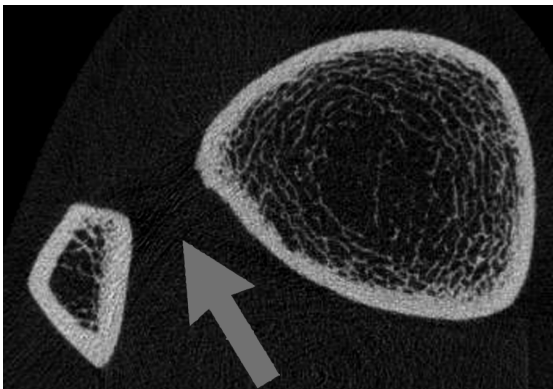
The representative grayscale images of a cylinder with uniform density with (A) and without (B) beam hardening artifacts (corrected by a BH correction algorithm). The corresponding line profiles (C) show characteristic cupping effect at the center (Adapted from Van de Casteel, 2004 [136]). As the x-ray beams pass through the thick cortex parallel to the streaks, the low energy x-rays were preferentially attenuated. Darker streaks between the tibia and fibula resulted (D).
